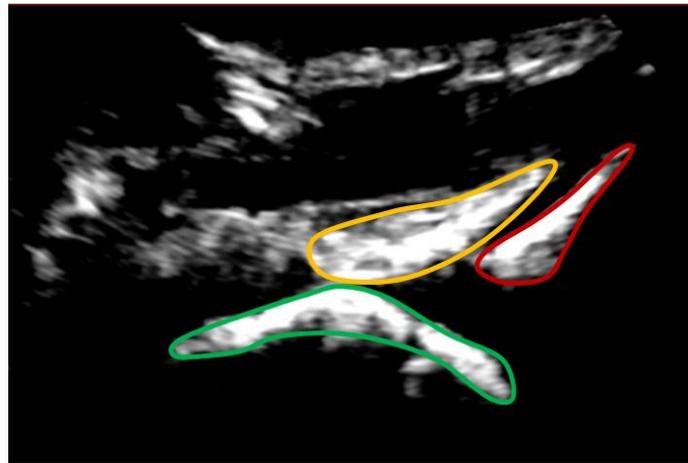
Identification of significant anatomy from sagittal plane ultrasound slice. Red = acetabulum, yellow = labrum, green = femoral head.
